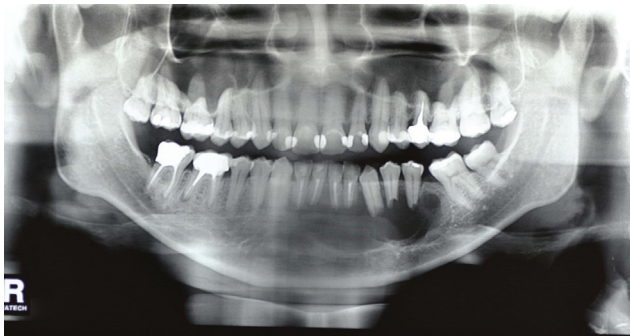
Panoramic Radiographic.
